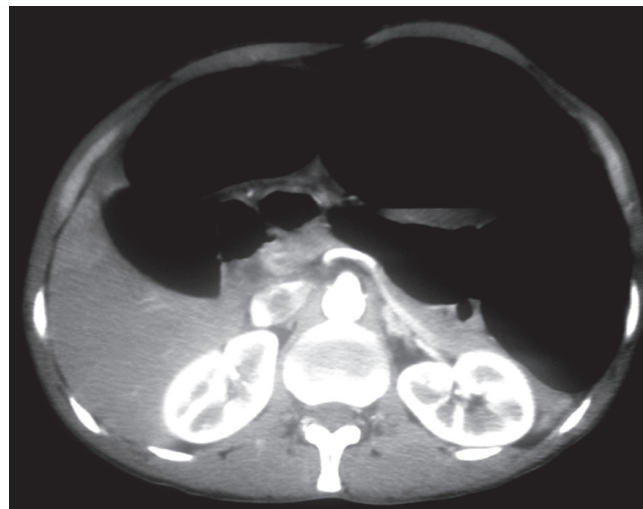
Axial CT image in SV (whirl pattern in sigmoid mesentery and dilated sigmoid colon segments).
